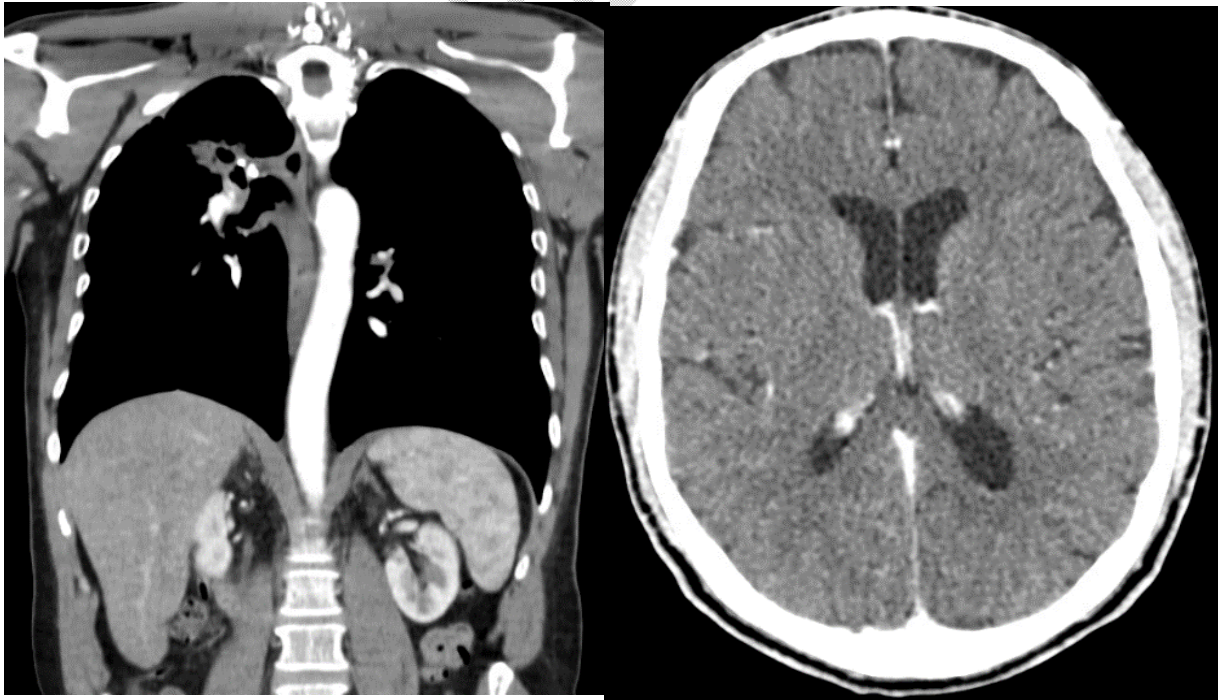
CT scan of the head and body conducted in 2019
